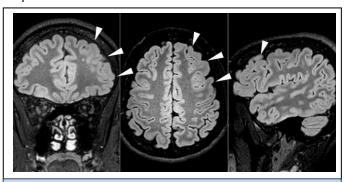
Magnetic Resonance Images (MRI) acquired on a 3 T scanner, FLAIR sequence, of the brain viewed from the side coronal (left), axial (central) and sagittal (right). White arrows indicated an area of hyperintensity localized at the posterior third of the superior frontal sulcus. FLAIR=fluid-attenuated inversion recovery.
